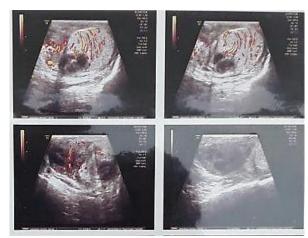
High-resolution Ultrasonography showed irregular ill-defined in heterogeneous soft tissue mass in the left testis with central hypoechoic areas without any flow detection
